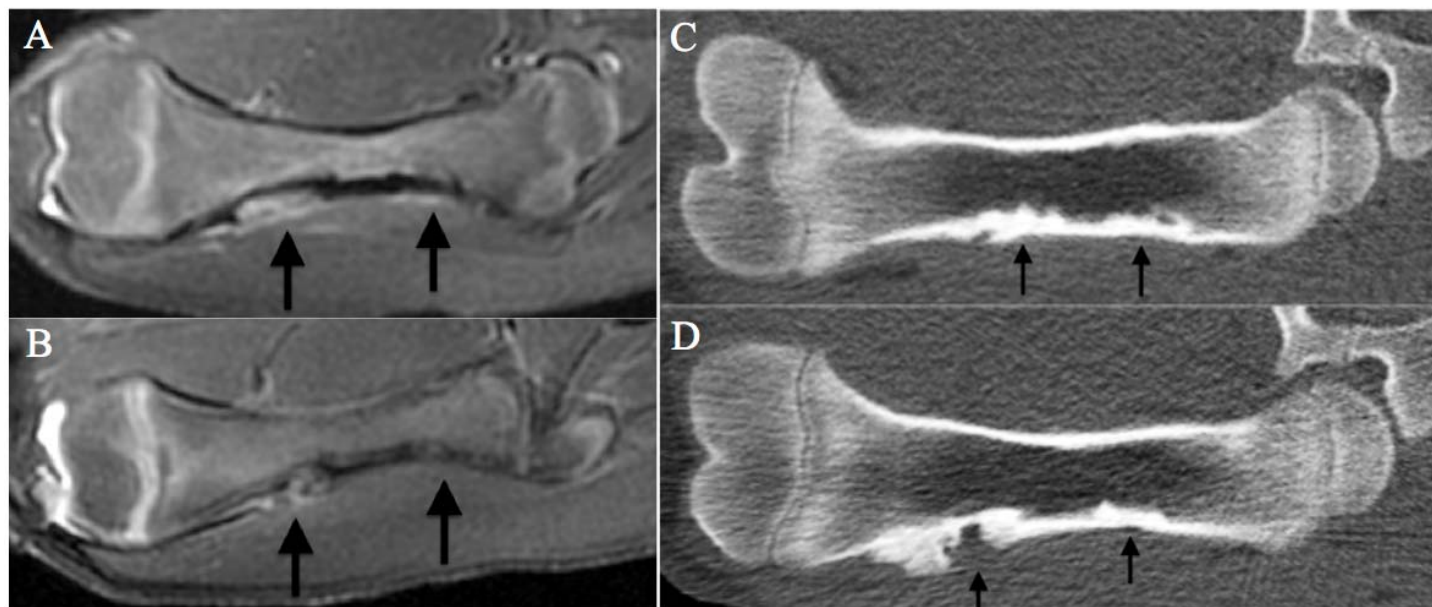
Representative coronal MR and CT follow-up images at 3 and 6 weeks status post MRgHIFU. A) T2-FSE at 3 weeks demonstrates focal T2 hyperintensity distally and subtle hyperintensity proximally. B) At 6 weeks a heterogeneous ovoid focus of T2 hyperintensity is seen and the proximal ablation is difficult to visualize. On CT, both ablations at 3 weeks C) demonstrate mixed endosteal sclerosis and lucency. D) At 6 weeks, there is evidence of new bone density along the distal, high energy lesion and compact endosteal sclerosis at the proximal ablation.
